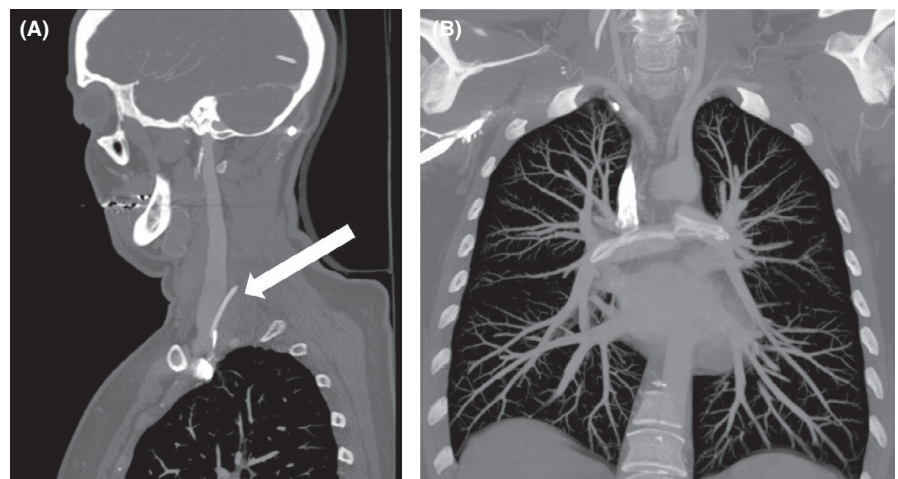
A, Computed tomography angiography of the neck in the sagittal plane demonstrating the point of entry of the distal ventriculoperitoneal shunt catheter into the caudal internal jugular vein (arrow). B, Computed tomography angiography of the chest in the coronal plane demonstrating the coiled distal shunt catheter within the bilateral pulmonary artery branches
